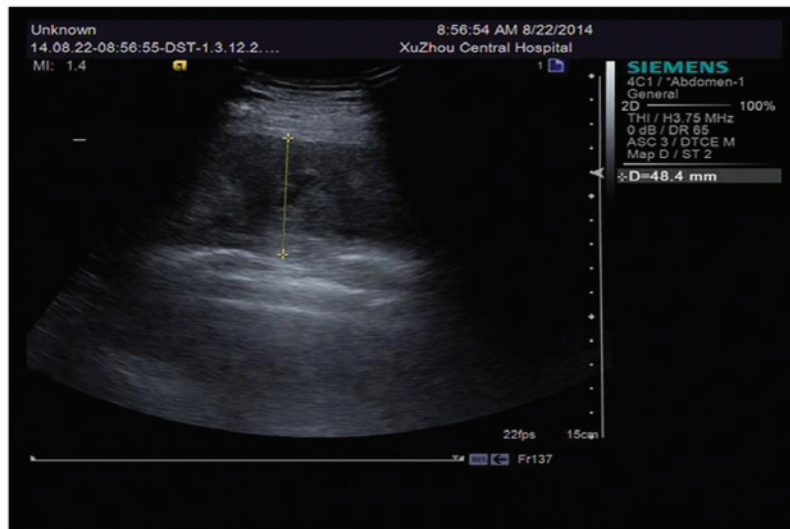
Liquid anechoic area under right scapula shown by ultrasonic examination.
